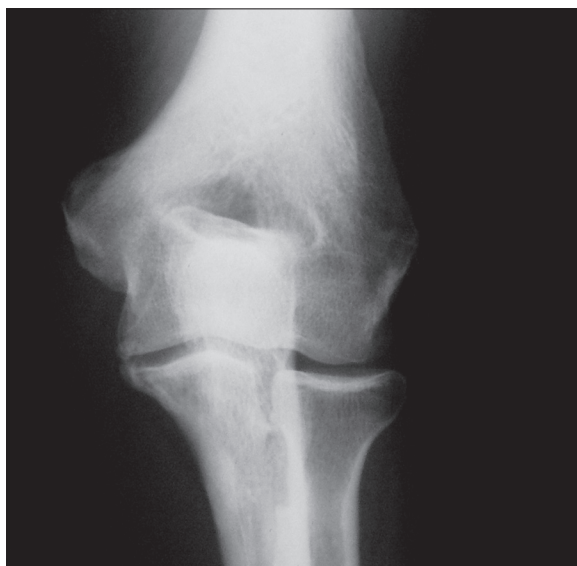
X-ray of cubital joint in a 56-year-old man with a 21-year history of psoriatic arthritis. Destructive changes are visible in the lateral epicondyle of the humeral bone in attachment of the extensors of the forearm.
